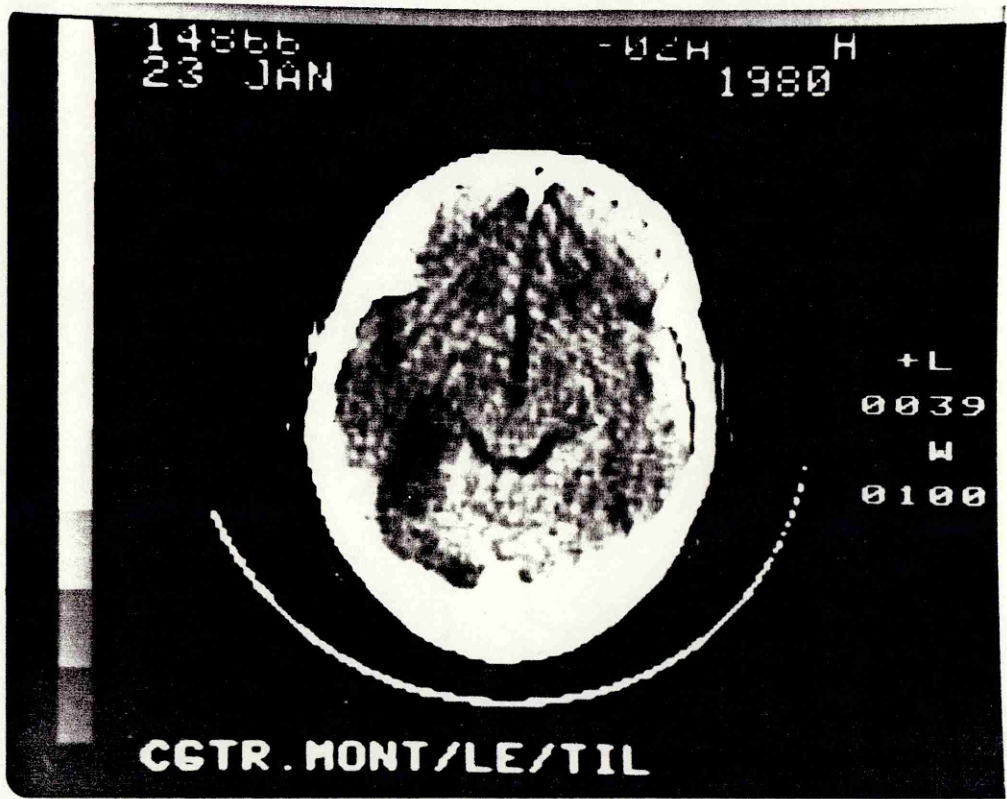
1b CT scan January 1980
